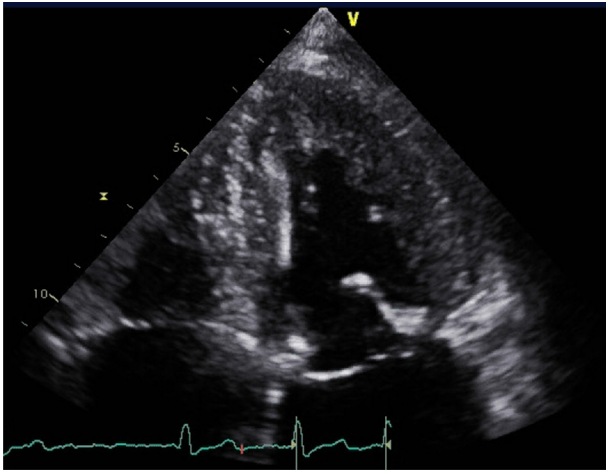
Transthoracic echocardiography: apical four-chamber view during end-systole showing resolution of the apical wall motion abnormality after 3 months.
